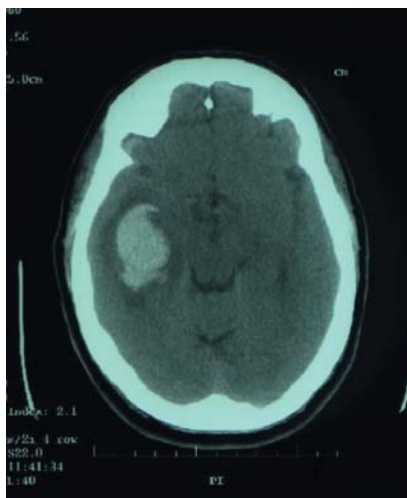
Presentation CT scan of a 68 year old patient with sudden onset left/right agnosia and symptoms of raised intracranial pressure. An intracerebral haemorrhage was identified in the right temporal region causing mass effect. He improved without haematoma evacuation.
